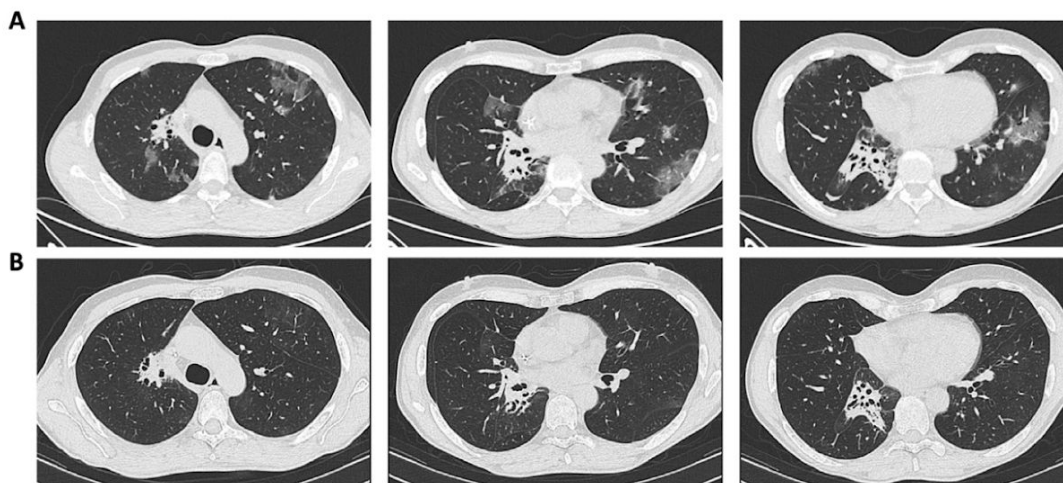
A) CT scan of Case 2 (lorlatinib for *ROS1*-positive NSCLC) performed on March 12th documented multiple bilateral subpleural ground-glass opacities in a crazy paving pattern, highly suggestive for SARS-CoV-2 pneumonia; B) CT scan after recovery of symptoms (April 9th) showed complete resolution of interstitial pneumonia.
